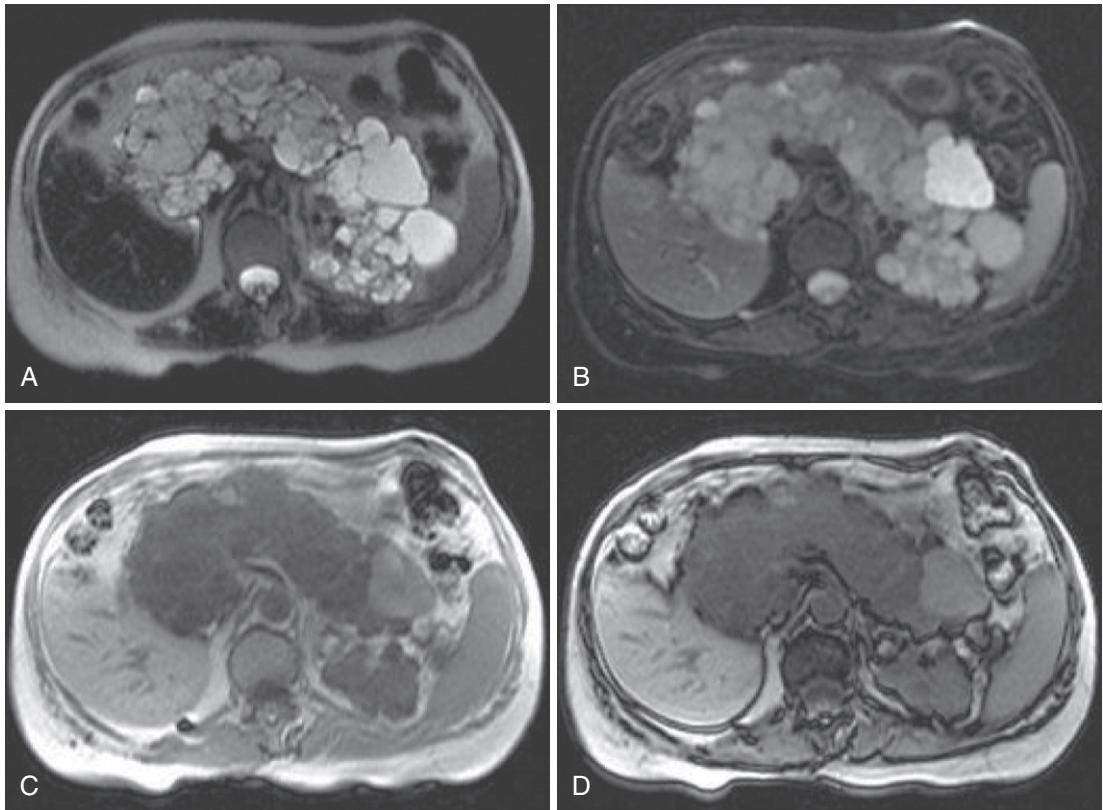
von Hippel-Lindau disease. T2-weighted (A), fat-suppressed T2-weighted (B), in-phase T1-weighted (C), and out-of-phase T1-weighted (D) images of cystic pancreatic replacement in a patient with von Hippel-Lindau disease.
